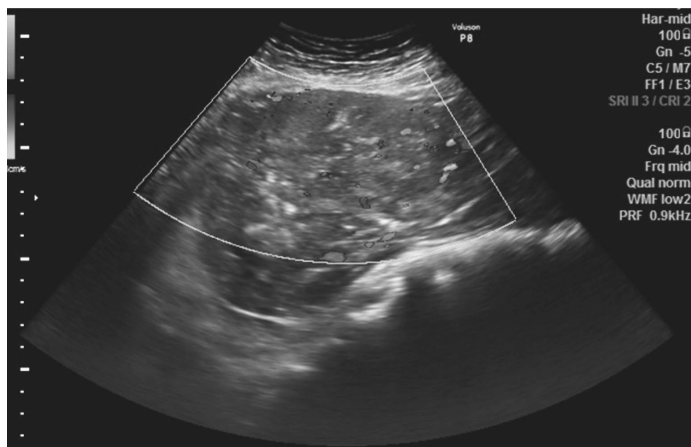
Color flow mapping of the abdominopelvic mass on transabdominal ultrasound revealed abundant intratumoral scattered branching vascularity.
